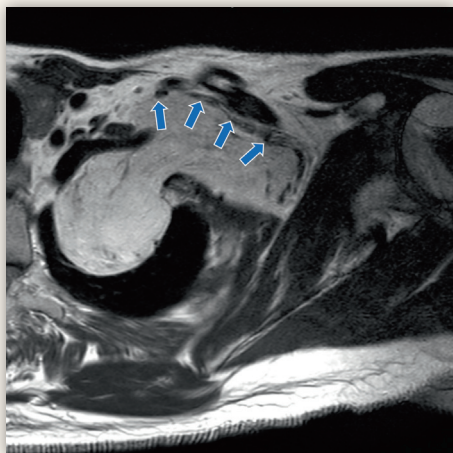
T1-weighted transversal MRI, demonstrating the pedunculated high-signal (fatty) mass entering the apical part of the left chest cavity. Note the anterior displacement of the axillary plexus (small arrows) and the dumbbell shape of the mass.
